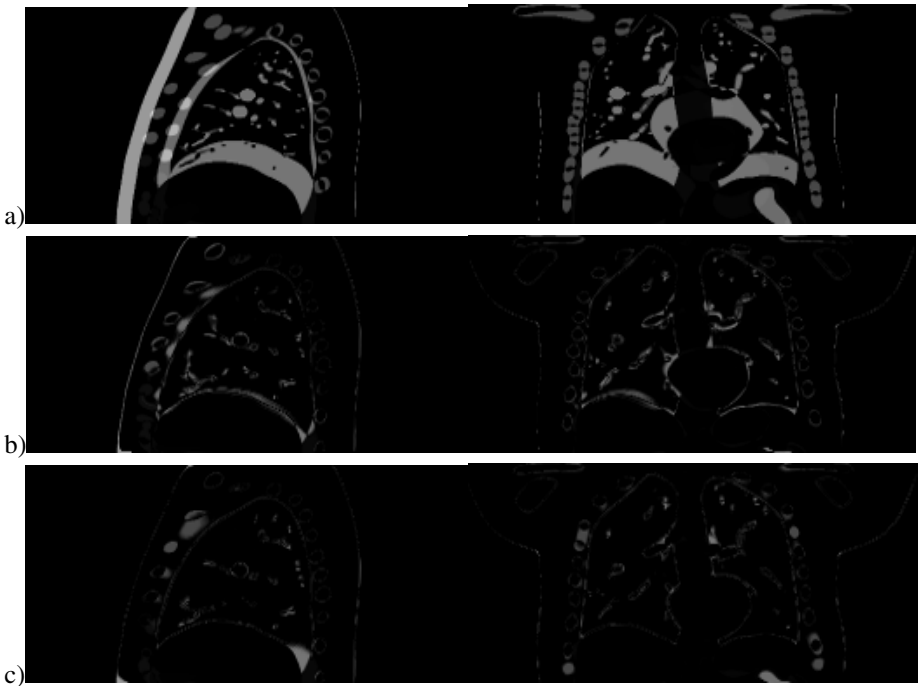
Left column: sagittal view of the absolute difference image between a), test and reference CT; b), test CT and CT reconstructed using proposed algorithm; c), test CT and deformed CT using demons. Tumor is a round object near the center of the slice. Right column: same as left column, except for coronal view. Tumor is a round object in the right lung.
